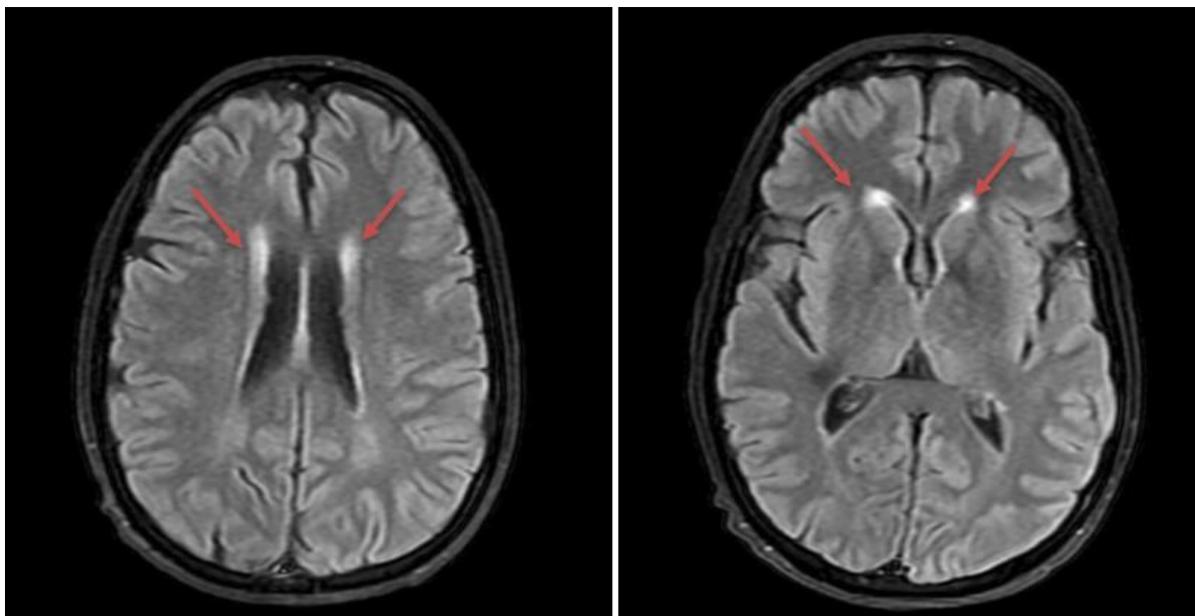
T2 FLAIR Axial images demonstrating minimal white matter changes (red arrows)
